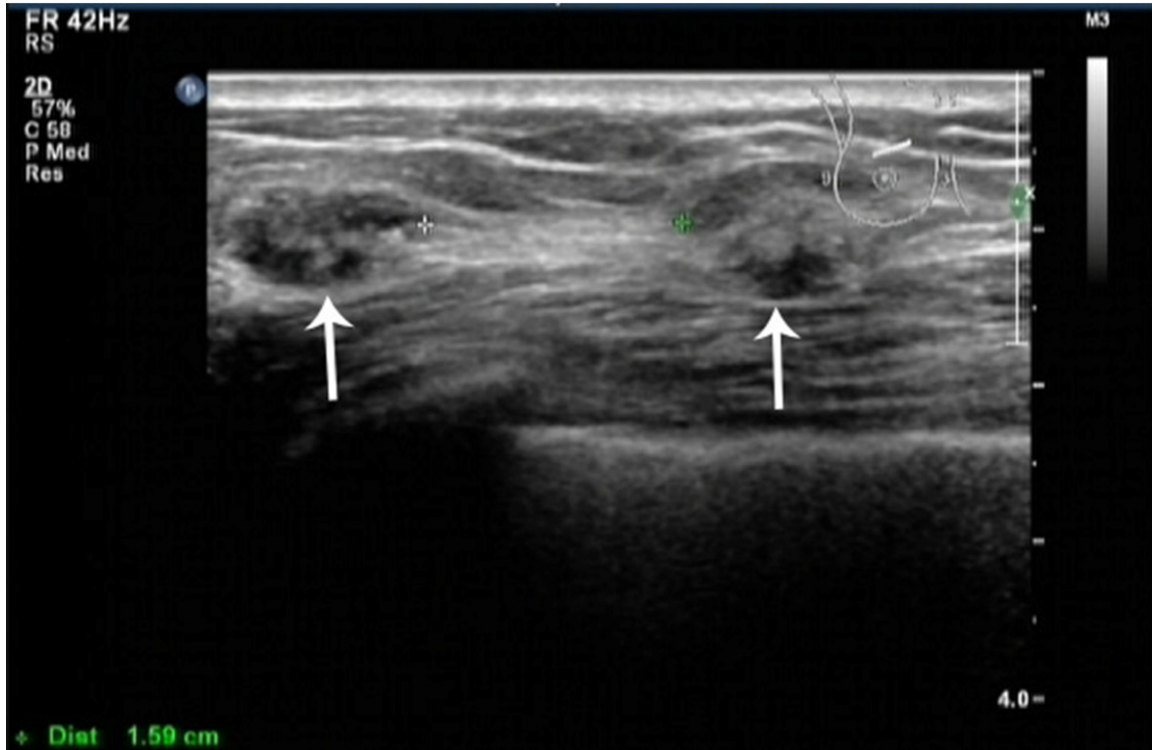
Ultrasonographic appearance of the right breast. The echogram shows two ovoid, hypoechoic masses with irregular internal echo (white arrow).
